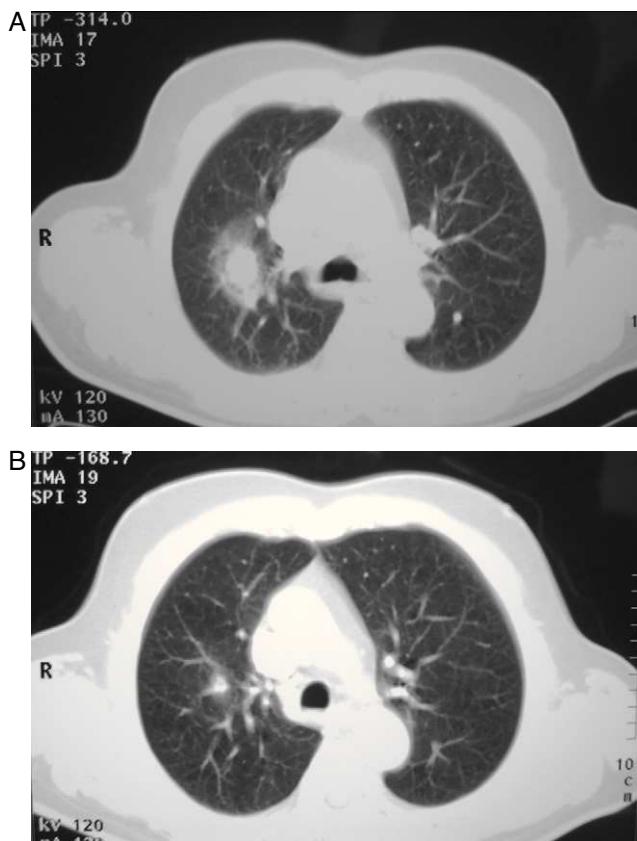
(A) Thoracic CT showed a nodule of 2 cm in upper right lobe with adjacent pneumonitis. (B) Thoracic CT fourteen days after onset revealed resolution of nodular image.
